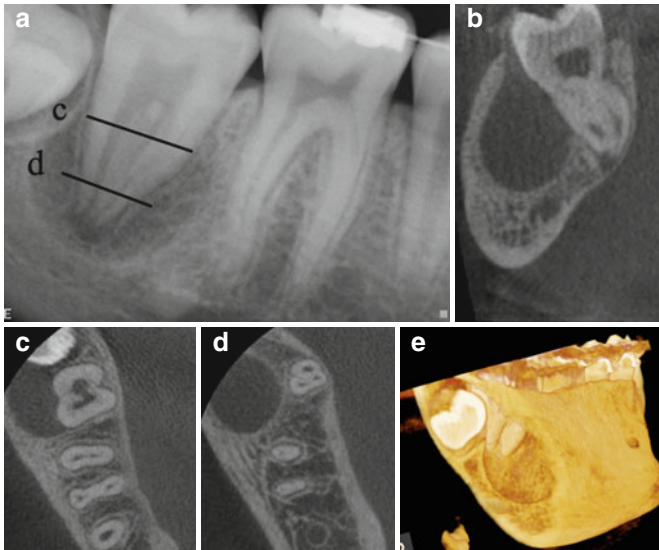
Continuation of case from Fig. 2.2. (a) Periapical radiograph of tooth number 31. (b) Coronal view showing the buccal location of the periapical radiolucency in relation to tooth number 31. Notice the apical 1/3 of the root is surrounded by bone which explains the positive response to cold and EPT. The *lines* on the periapical radiograph correspond to the axial section views *c* and *d*. Axial sections *c* and *d* demonstrate the origin of the lesion as tooth number 32. 3D reconstruction (*e*) demonstrates the buccal location of the lesion and explains the isolated deep periodontal probing on the buccal aspect of tooth number 31
